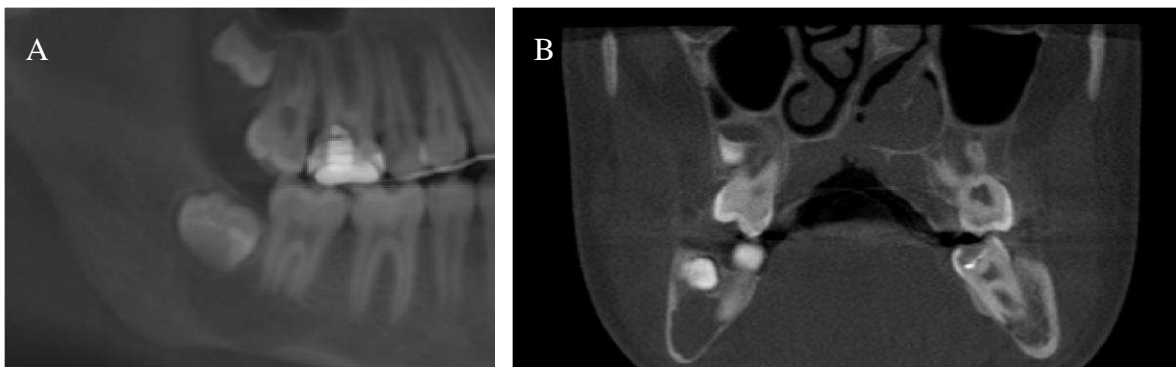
(A) Initial radiographic and (B) tomographic aspect showing a translucent central lesion on the right basal region
